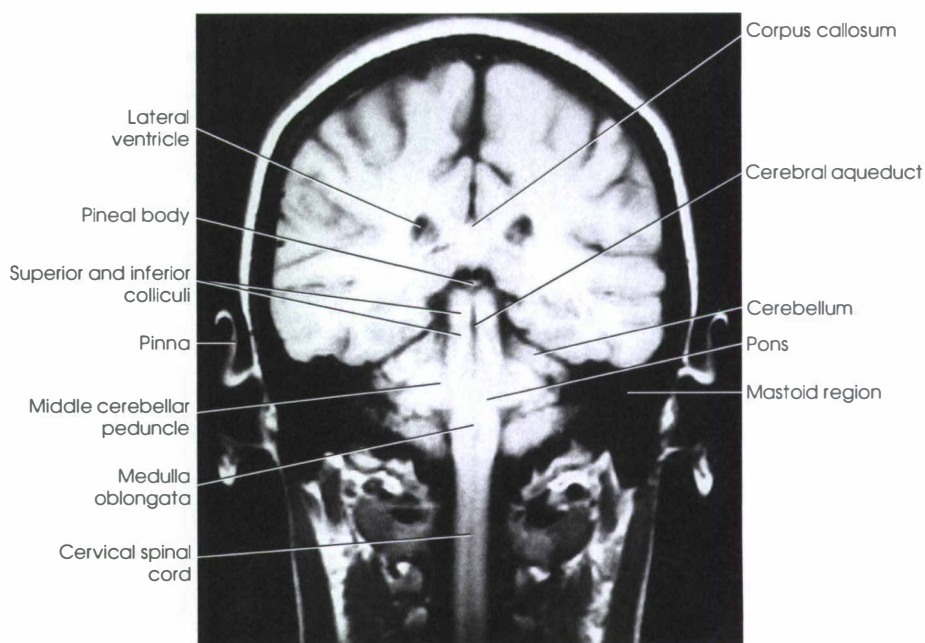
Coronal MRI corresponding to level C in Fig. 27-14.
